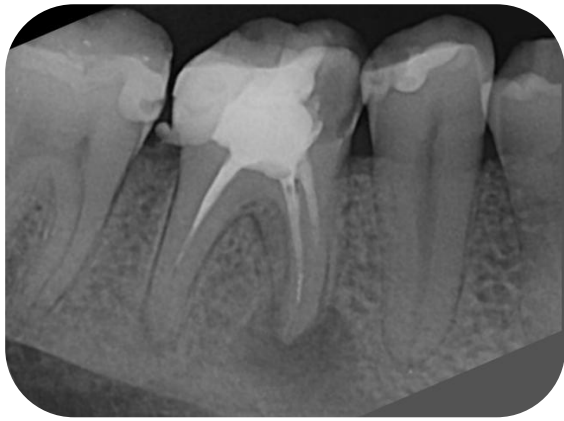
An intraoral parallel periapical preoperative radiograph of tooth #46 - PAI (Periapical index) score 5
